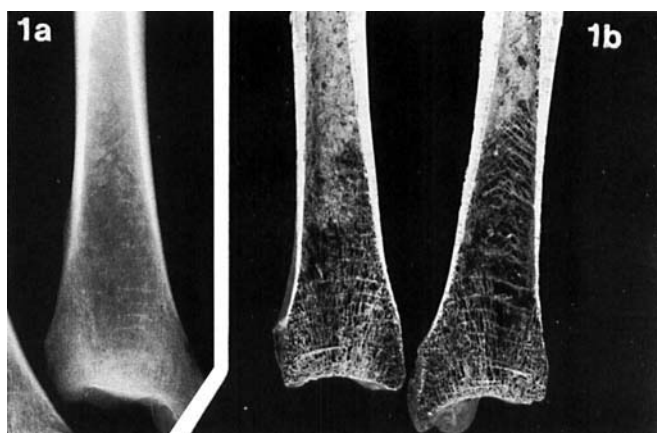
Transverse lines in the distal tibia of an adult (A191) buried in Waterford in the 17th century. a: On radiograph. b: Macroscopically in section.
